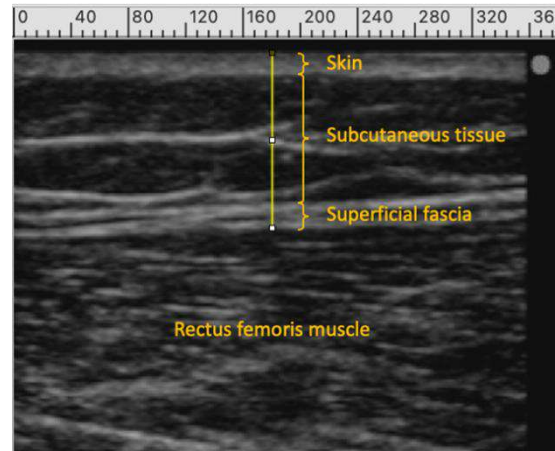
Representative ultrasound image showing the measurement of overlying soft tissue thickness in the evaluated muscle (rectus femoris in this example). Measurements were performed using ImageJ software.
